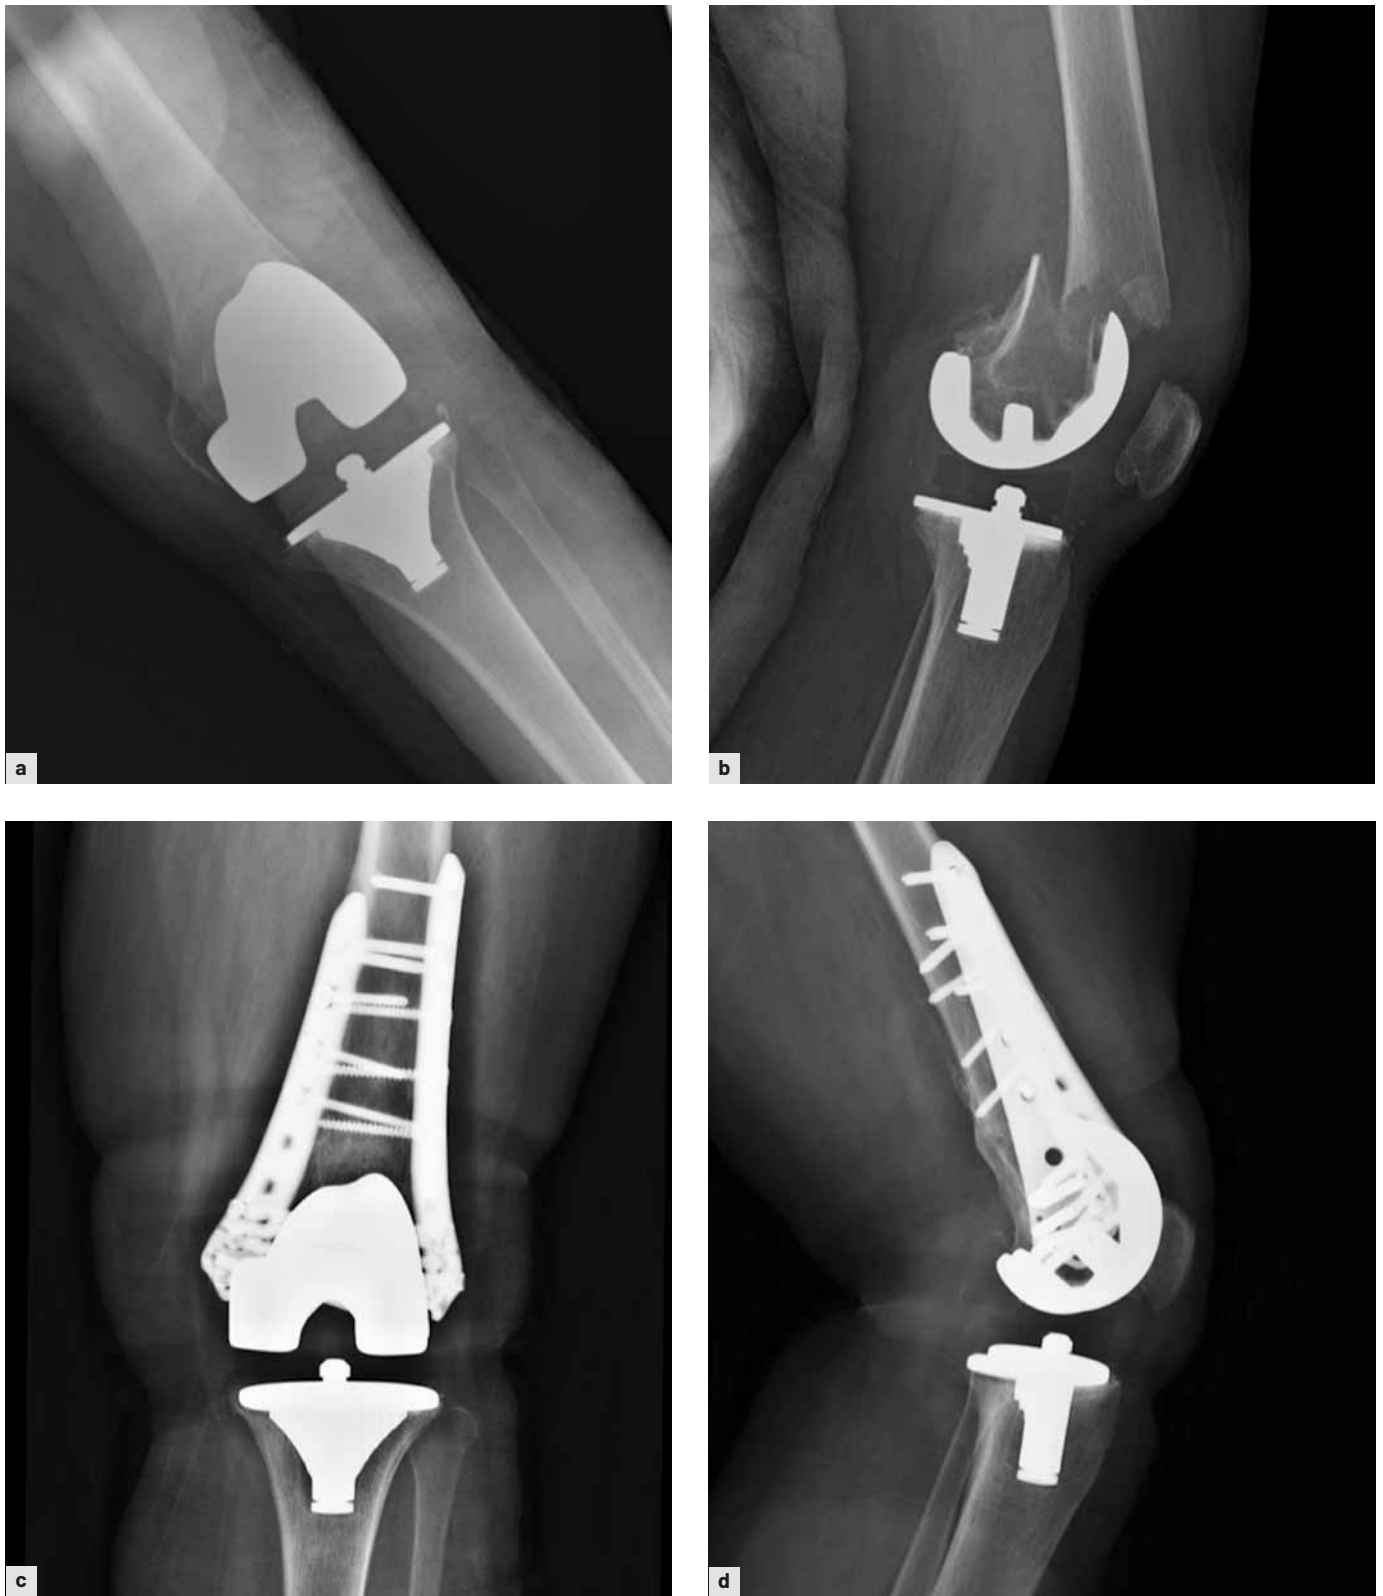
a, b – preoperative X-rays of the patient with periprosthetic fracture with Su classification type II. c, d – postoperative radiographs at 7 months confirmed union with medial, lateral, and posterior callus bridging.
